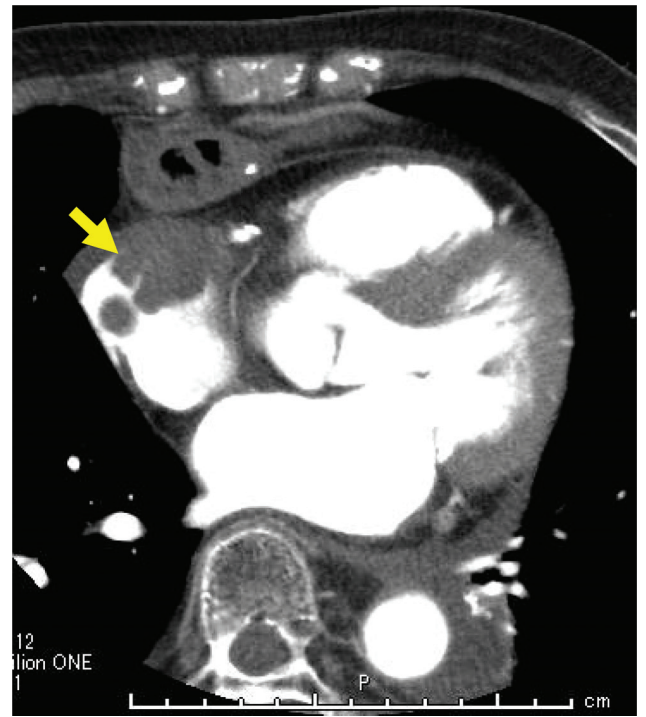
Contrast-enhanced CT demonstrating an irregularly shaped defect of contrast material inside the right atrium (arrow). CT: computed tomography
